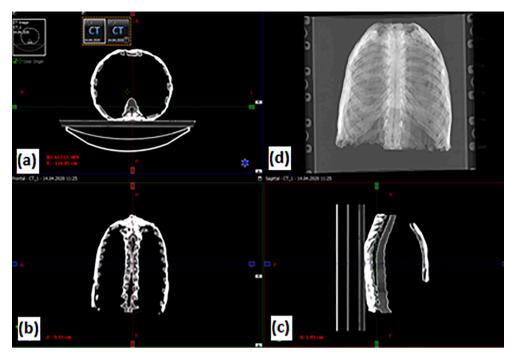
CT scan of the thorax, (a,b,c) Respectively axial, coronal and sagittal slice, (d) Topogram.
